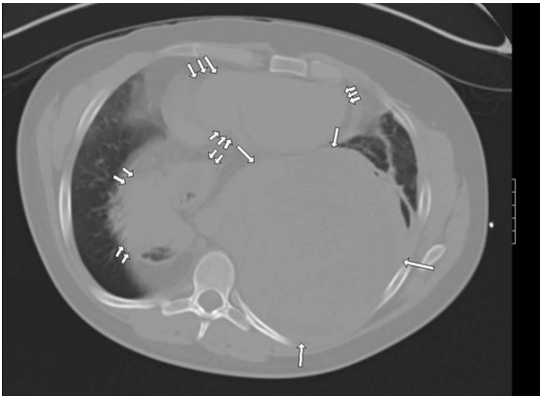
Axial non-contrast chest CT in a lung window. This image demonstrates the same findings as described in Figure 1, including a large extrapulmonary intrathoracic mass compressing the heart and displacing the left lung. The lung window provides improved visualization of the pulmonary parenchyma and air spaces, highlighting associated left lung atelectasis. The mass does not appear to invade the lung tissue.
